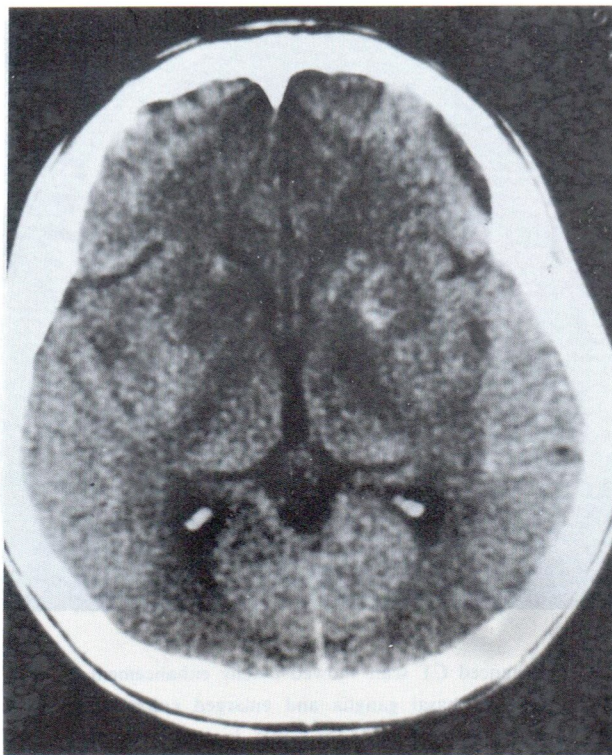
Enhanced CT scan shows enhanced infarction at both basal ganglia, in tuberculosis.
